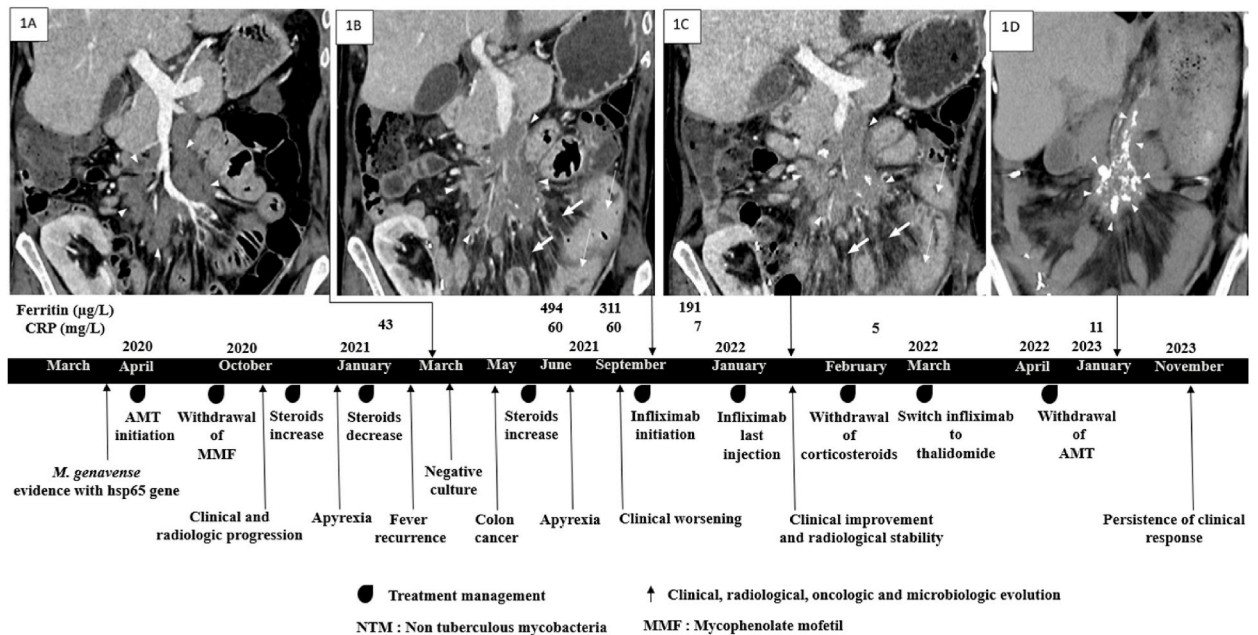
Timeline and images of patient one (1A-1D). CT-scan before (1D) and after (1A-1C) contrast enhancement (Iomeron 350, Bracco Imaging France) at the portal phase. In March 2021, we found a significant increase of celio-mesenteric lymph nodes (arrowheads) (1A). In October 2021, views showed a worsening of mesenteric lymph nodes (arrowheads) with comb sign, mesenteric infiltration (thick arrows) and bowel thickened (thin arrows) (1B). In February 2022, we can notice a stability of the radiological pattern (1C). In January 2023, we observed a non-active calcifying evolution of mesenteric lymph nodes (arrowheads) (1D).
